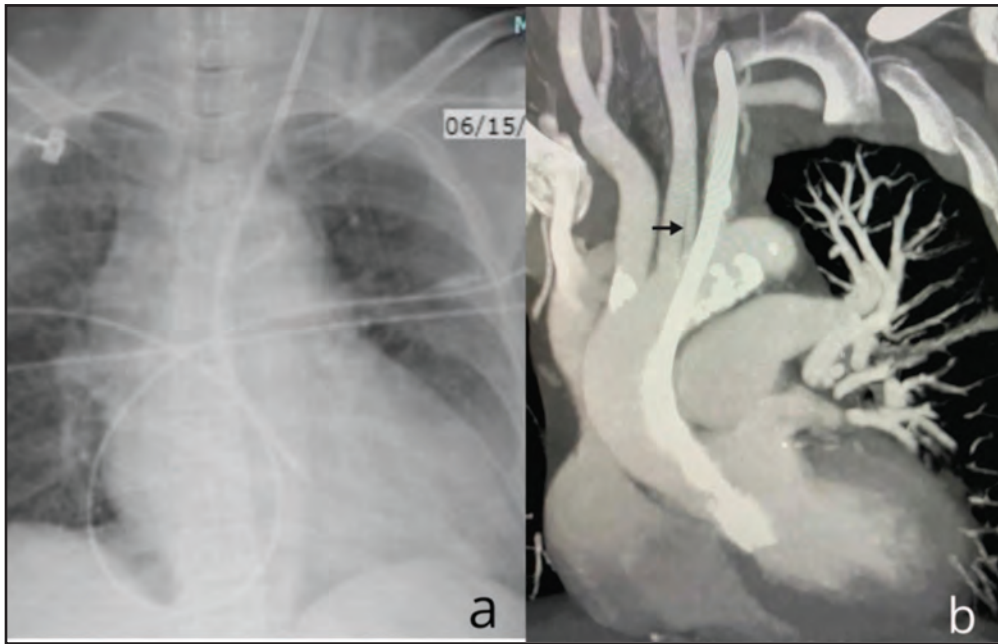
Chest x-ray showing the course of CVC(a) and CTA showing CVC in left ventricle(b) with an aberrant left vertebral artery arising from arch of aorta(arrow)
